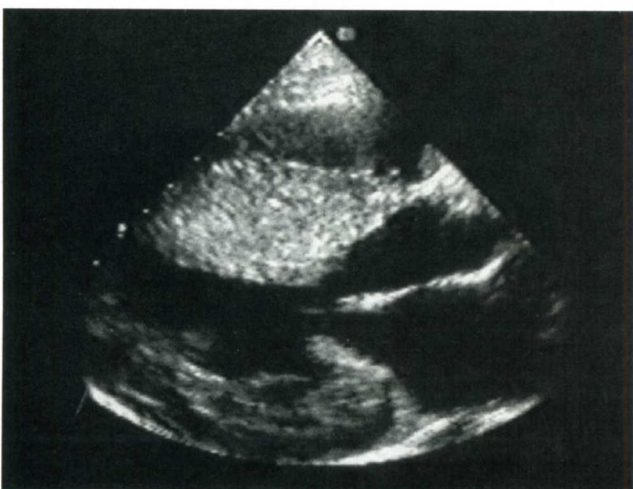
Assymetric septal hypertrophy. A thickened, echogenic LV septum is noted in PSL view in a patient with this condition (also known as IHSS). (Courtesy of Lori Sens and Lori Green, Gulfcoast Ultrasound)
